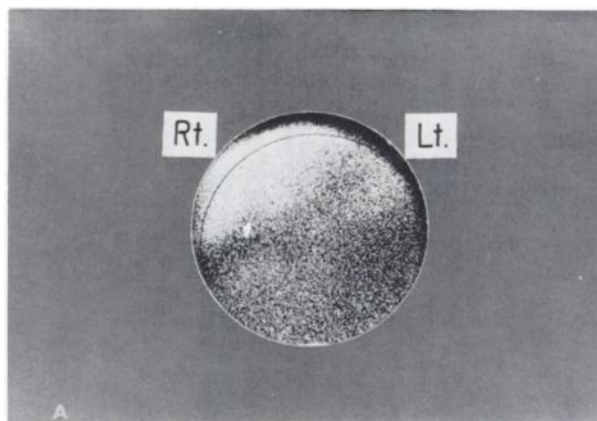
A is scintiphoto demonstrating markedly diminished uptake of ⁷⁵Se-selenomethionine in body of pancreas with poor localization of isotope in head. B, selective celiac study, shows splaying of gastro-epiploic arteries with corkscrew terminations indicating large space-occupying lesion in region of pancreas. C shows large pancreatic pseudocyst discovered at exploratory laparotomy. Radiograph shows outline of cyst by contrast material injected at surgery.
